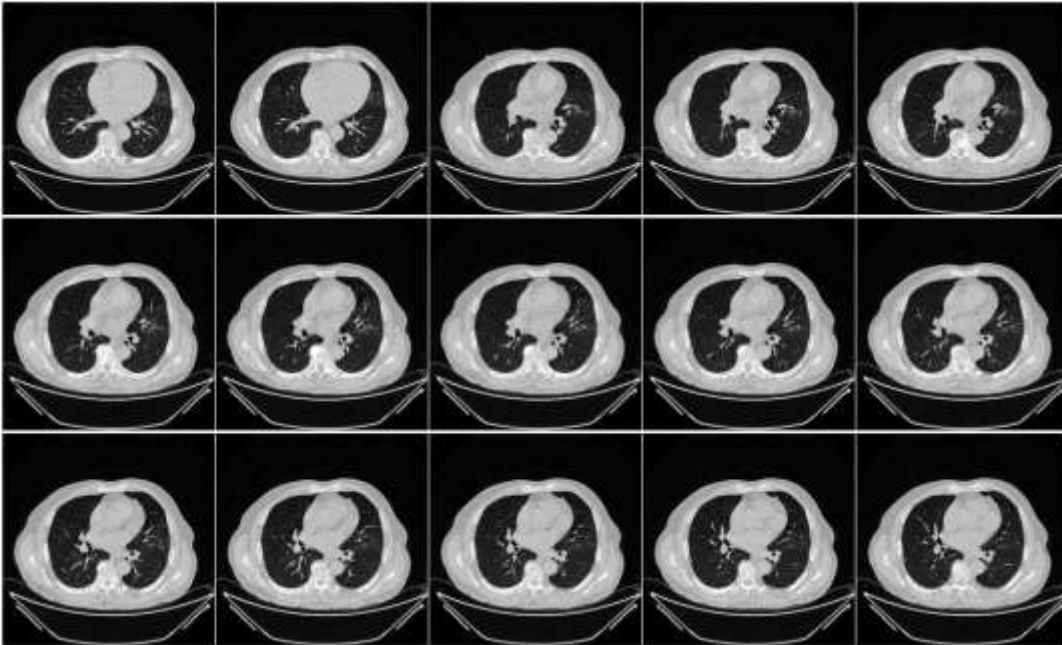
Raw “COVID-19 CT lung slices” taken from the NovMED dataset.
